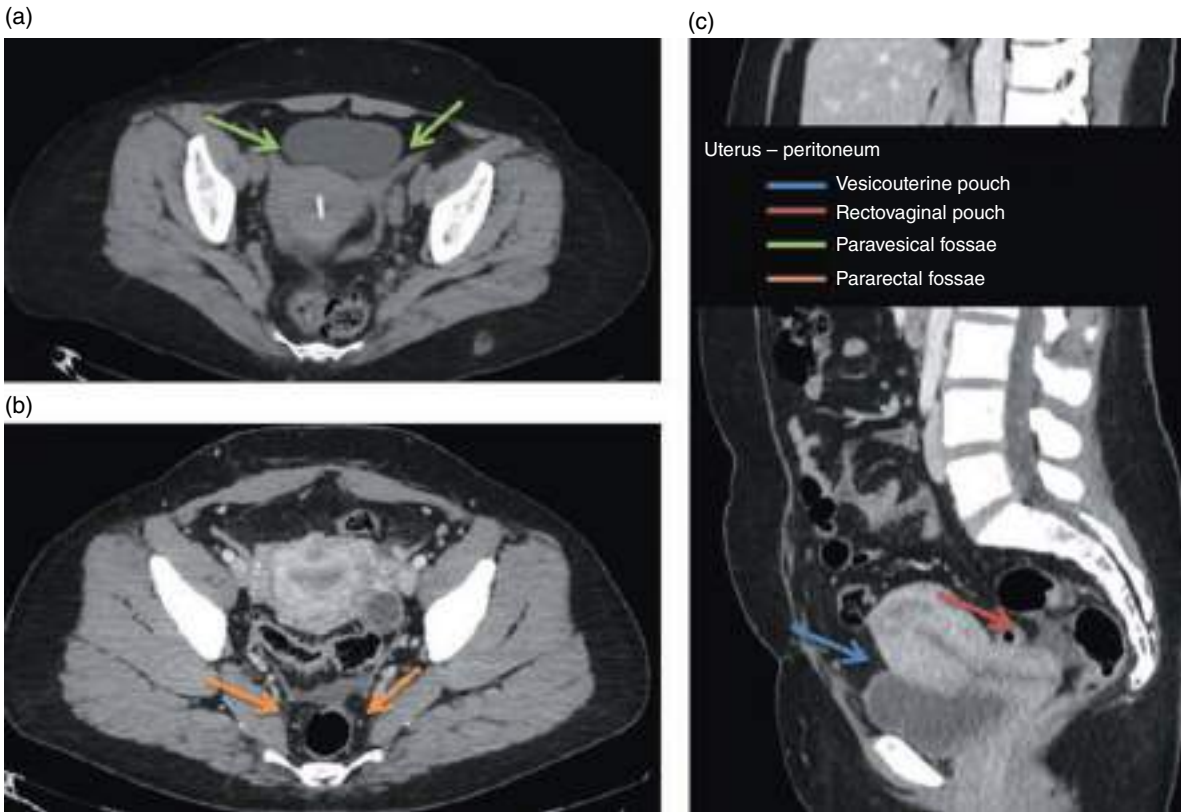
Uterus and peritoneum. (a) Axial noncontrast CT image. (b) Axial contrast-enhanced CT image (portal venous phase). (c) Sagittal contrast-enhanced MPR CT image (portal venous phase).
